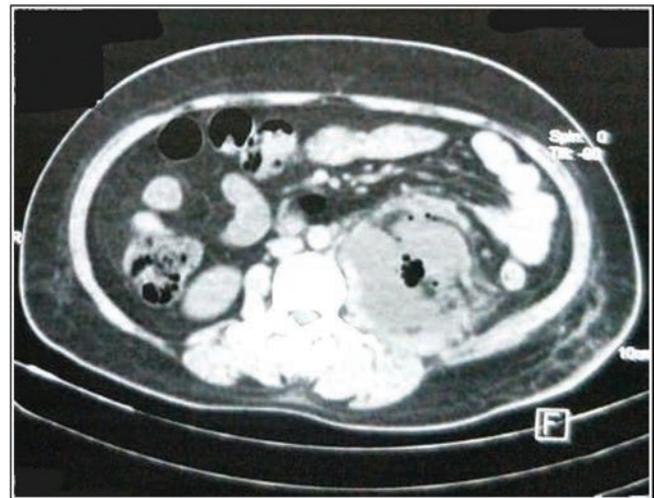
CT scan showing class 1 EPN with gas confined to the pelvicalyceal system of the left kidney
